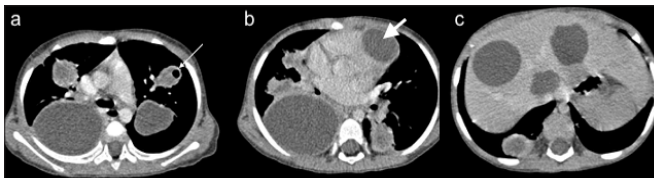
A-C. Selected slices from axial post-contrast CT-scan of the chest at the level of the (a) carina, (b) the aortic root (c) upper abdomen. Bilateral pulmonary large cysts are confirmed with more smaller lesions, in both upper lobes and the left lower lobe apical segment. The lesions are cystic, and there is no enhancement related to the internal or peripheral aspects of the lesions, in keeping with multifocal lung hydatid disease. (a) There is some gas noted within the non-dependent portion of the left upper lobe lesion suggesting erosion into a bronchus (long arrow). (b) A cardiac hydatid positioned within the left ventricular chamber is demonstrated (short arrow). (c) Multiple, varying-sized, similar appearing, non-enhancing, cystic lesions are noted in the imaged portions of the liver in segments VII, IV and I of the liver, in keeping with hepatic hydatid disease.
